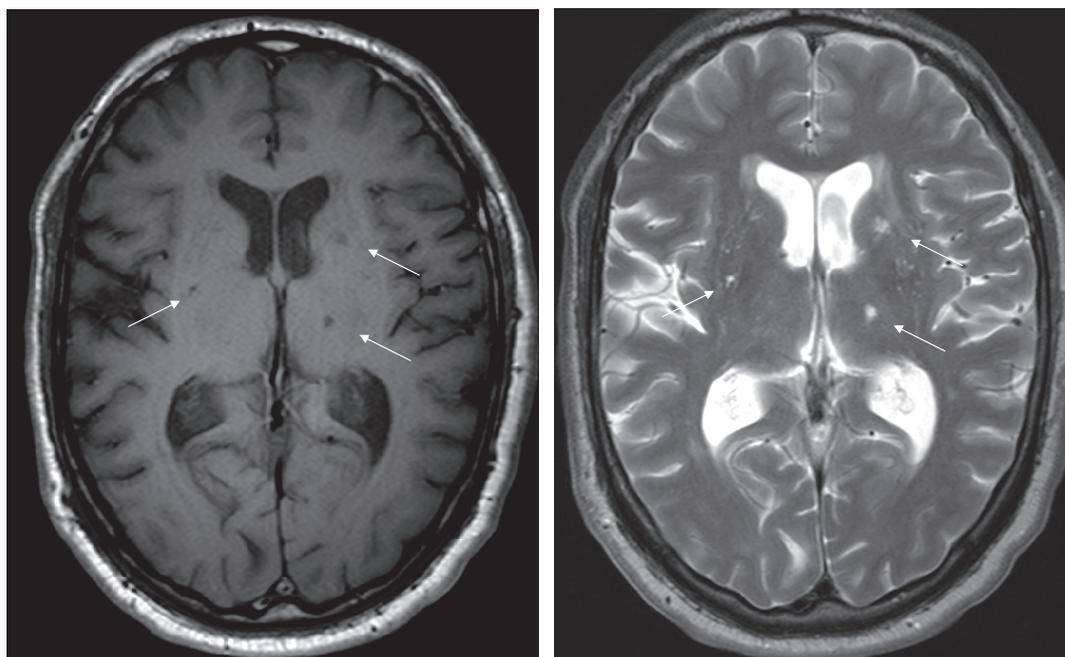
Silent infarcts (arrows) in bilateral basal ganglia regions on MRI T1 (left) and T2 (right). Courtesy of Stig Holtås, Lund.
